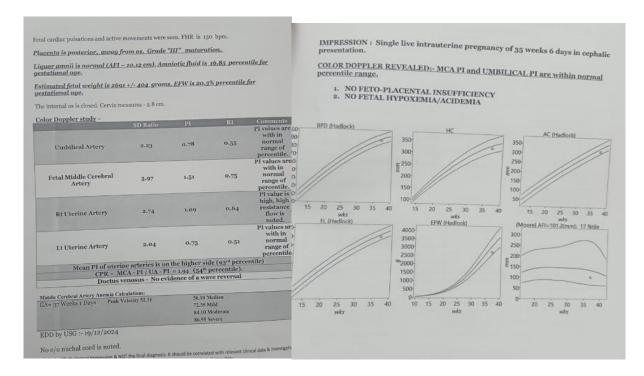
After treatment: Ultrasonography reports
